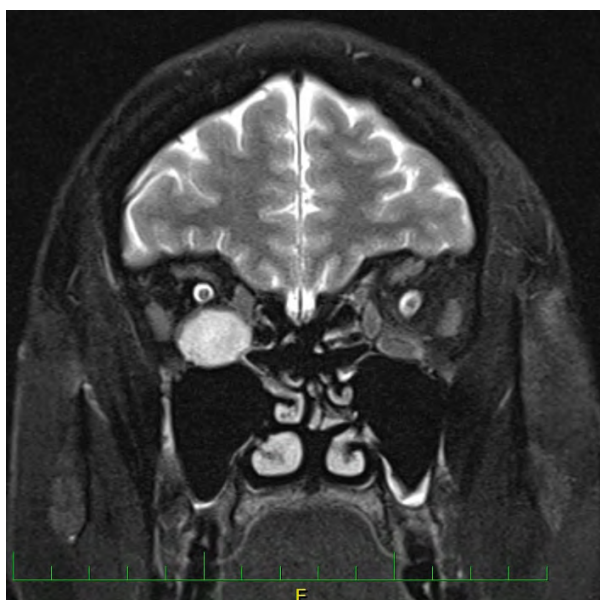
Magnetic resonance image of orbital haemangioma, coronal view
